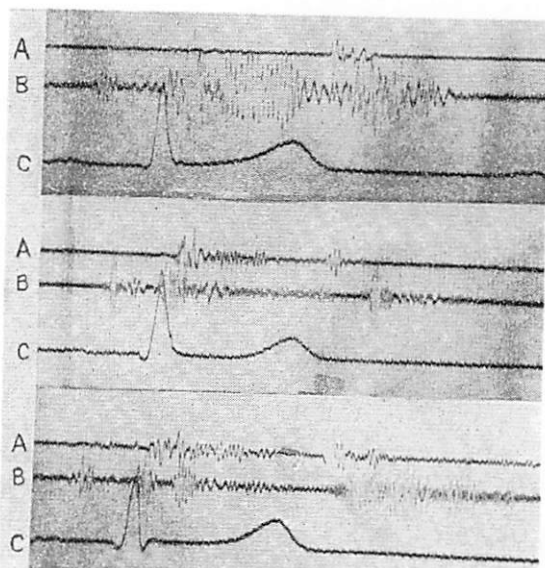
Oscillograms; the lower frequency Doppler signal, the higher frequency Doppler signal, and the Doppler heart noise, respectively. (A—heart sound, B—Doppler signal, C—E. C. G.)
